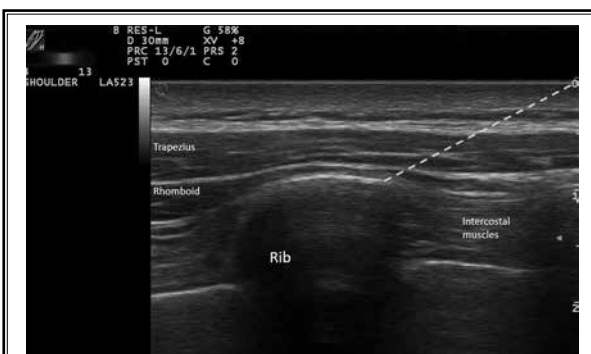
US image of an injection (rib, pleura, fascia below the rhomboid, needle, injectate). US: ultrasound.
